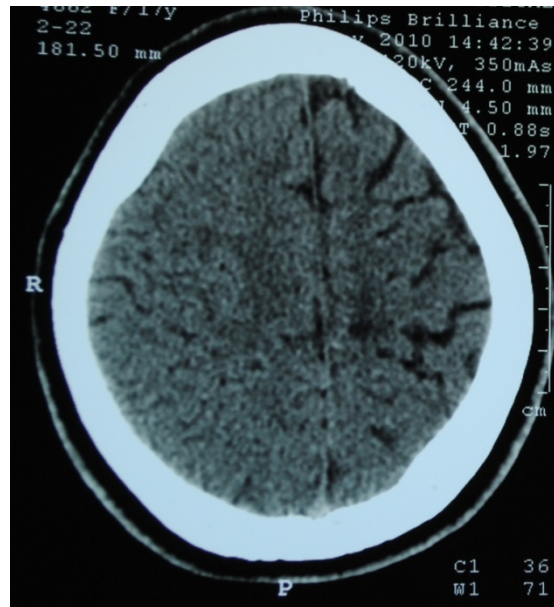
Plain CT Head showing widening of the sulci and atrophy of gyri of left cerebral hemisphere
